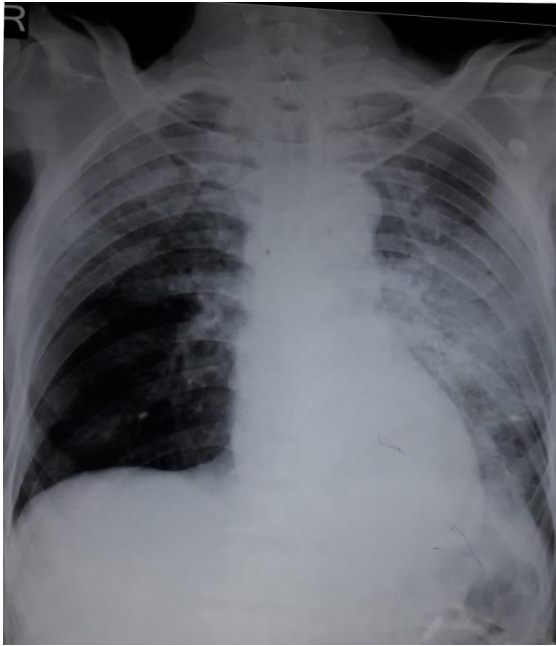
The chest radiograph is showing miliary mottling opacity in left lower 2/3rd and upper 1/3rd in the lungs.
